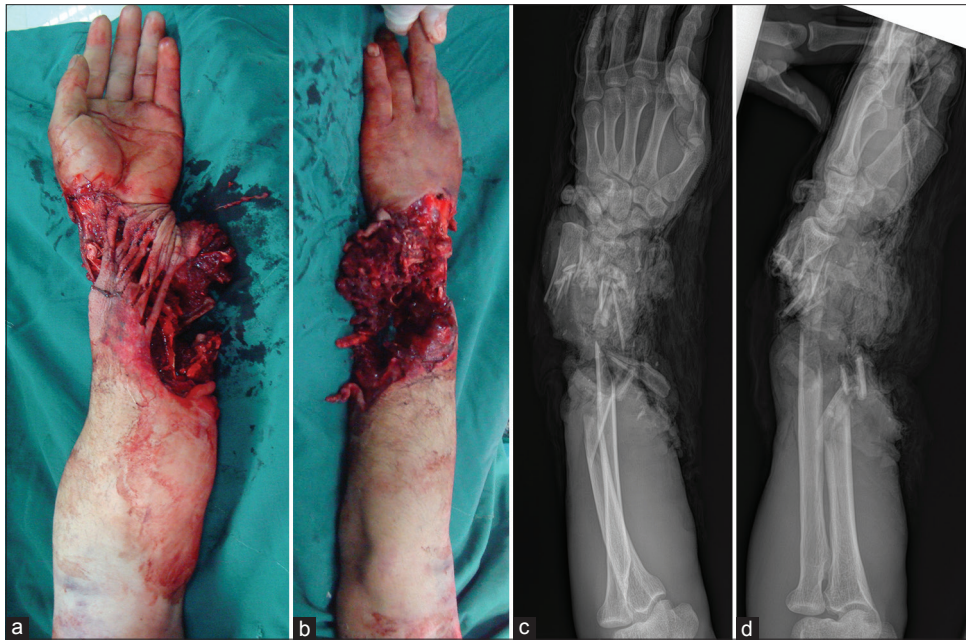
Extensive and complex crushing injury to the wrist and forearm. (a) Volar view; (b) dorsal view; (c) anteroposterior radiograph; (d) lateral view
